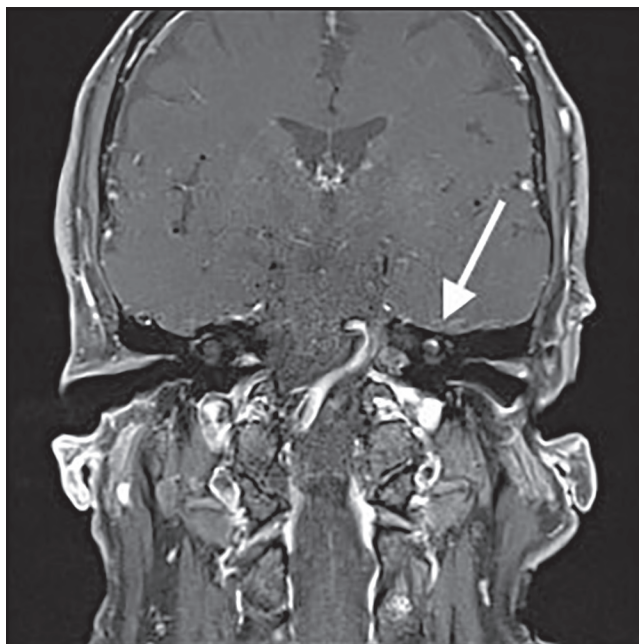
MRI scan displaying presence of left intracochlear schwannoma.
